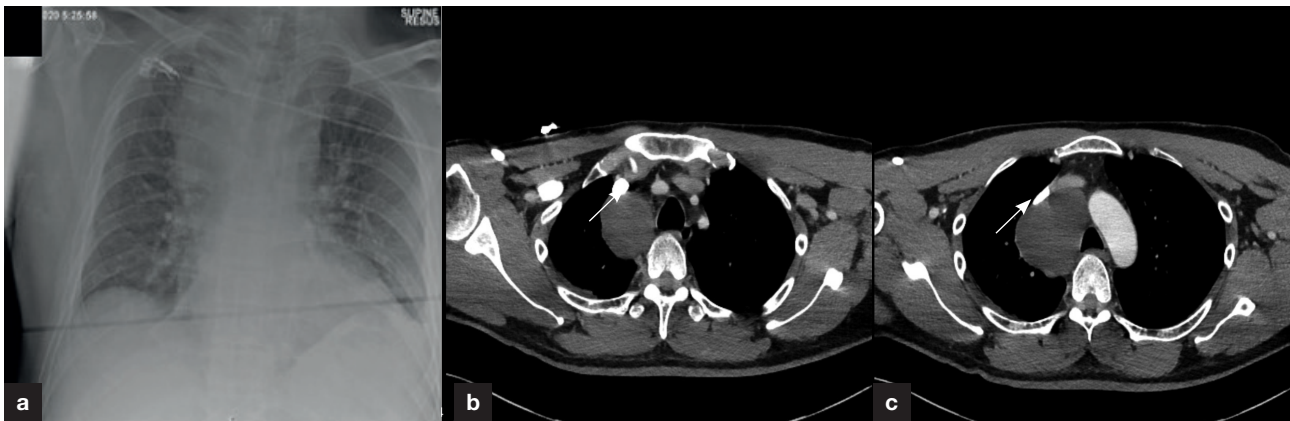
a. Plain chest radiograph supine anterior-posterior image shows widened mediastinum. b. Computed tomography showing a low to intermediate density mediastinal lesion (arrow) measuring 75 × 63 mm transaxially, (c) centred in the right paratracheal region compressing the superior vena cava.
